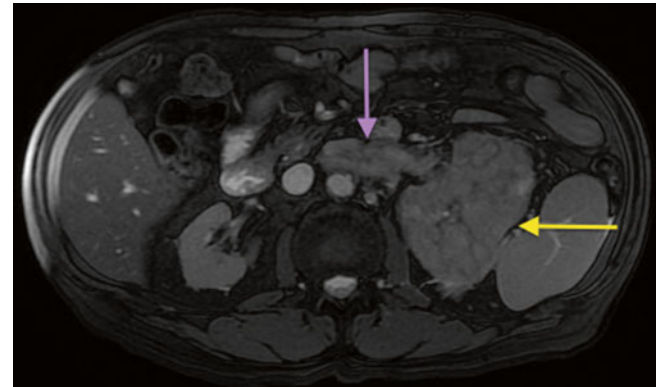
Renal cell carcinoma with renal vein invasion. Axial “bright-blood” balanced gradient echo image demonstrates a large mass involving the left kidney (*yellow arrow*) with expansion of the left renal vein compatible with tumor thrombus (*purple arrow*). Note the difference in signal between the tumor-infiltrated left renal vein and the patent inferior vena cava. In patients who cannot receive intravenous contrast for MRI due to renal insufficiency, non-contrast imaging, including conventional, diffusion-weighted, gradient echo, and even MRA sequences, can often provide substantial information as compared to unenhanced CT scan
